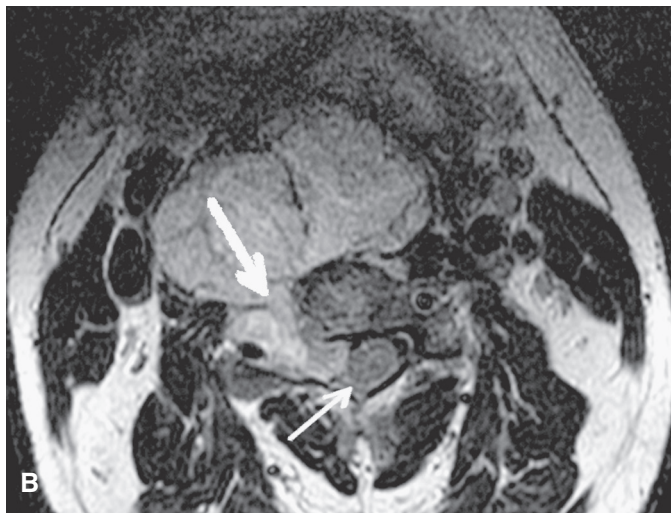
A 29-year-old man with large, invasive cervical spine chordoma. *A:* Axial, enhanced CT scan shows displacement and partial encasement of the right vertebral artery (*arrow*), displaced airway and esophagus (*asterisk*), and displaced right carotid artery and jugular vein (*letter V*). *B:* Axial, T2-weighted MR image shows the prevertebral mass extending through C3/C4 right neural foramen (*thick arrow*), destroying articular pillars, and extending into spinal canal with deformity and displacement of cord (*thin arrow*) to left.
